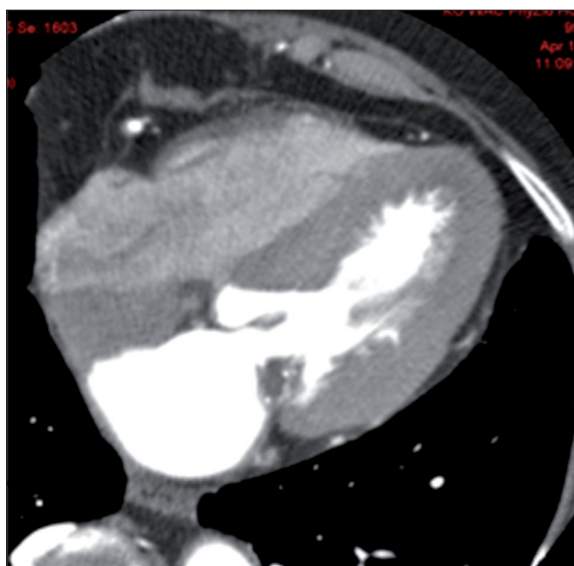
Caseous mitral annular calcification: Computed tomography.
